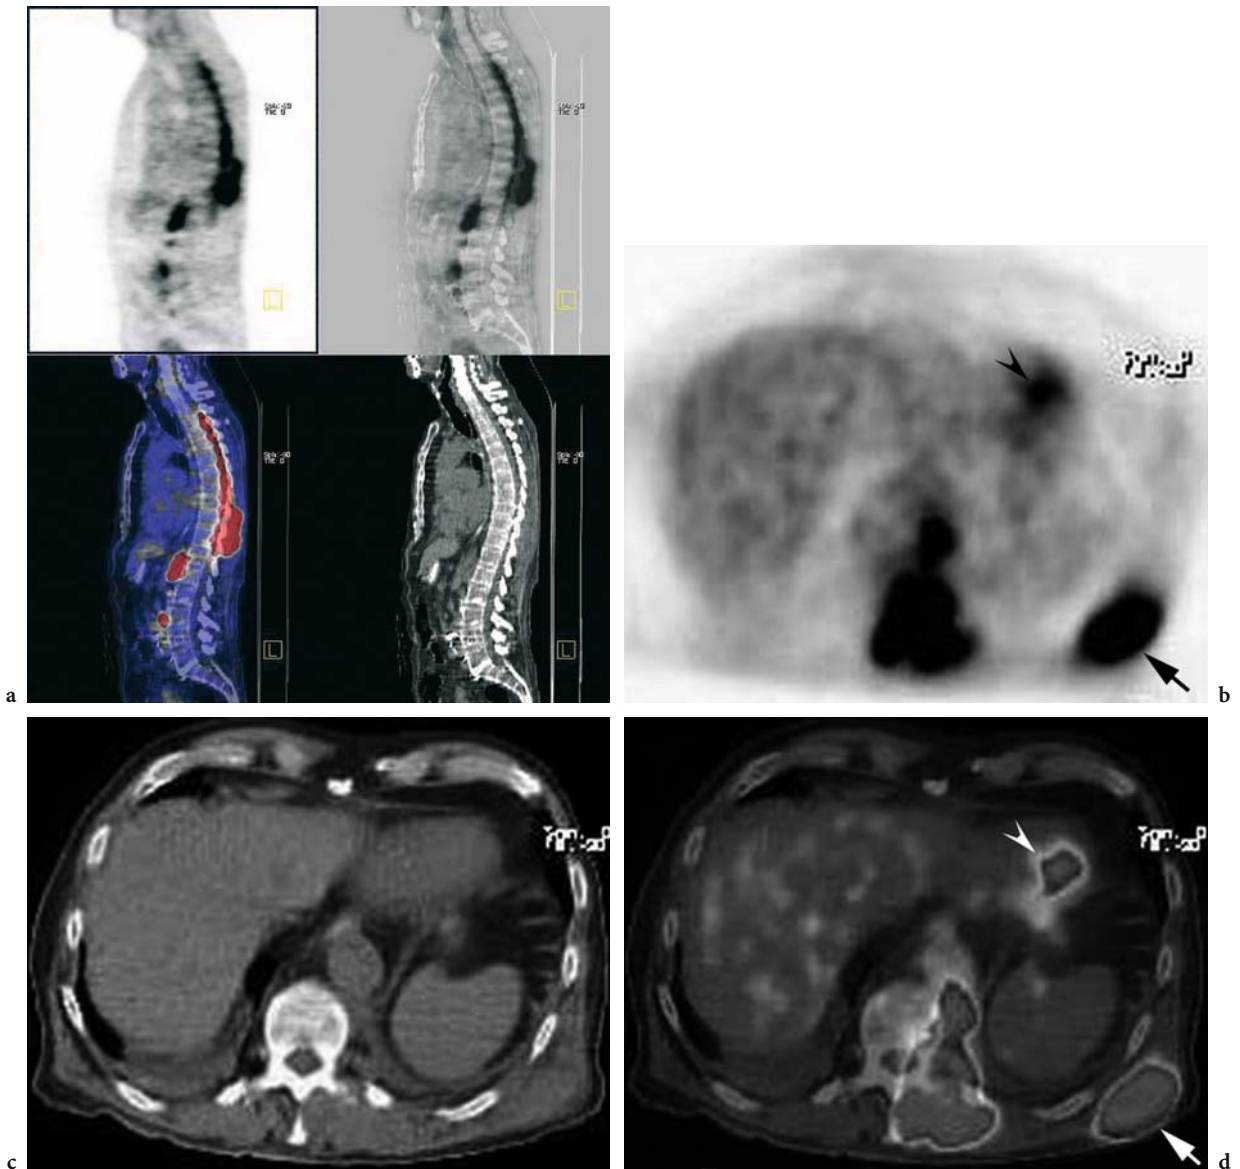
Epidural and muscle metastases in an 82-year-old man with a history of transitional cell carcinoma treated with left nephrectomy. a Sagittal PET/CT images demonstrate intense hypermetabolism along the distribution of the epidural space from T1 to T10 (*upper left panel: FDG-PET alone; upper right panel: combined more PET and less CT; lower left panel: combined less PET and more CT; lower right panel: CT alone*). Axial b PET, c CT, and d fused PET/CT images show the disease at the lower thoracic level, and also disclose disease in the left latissimus dorsi muscle (*arrow*). Note the normal anterior uptake of the heart (*arrowhead*). A subsequent MR imaging of the thoracic spine (not shown) confirmed the epidural disease without evidence for metastatic cord compression. (Image courtesy of H. Jadvar)
